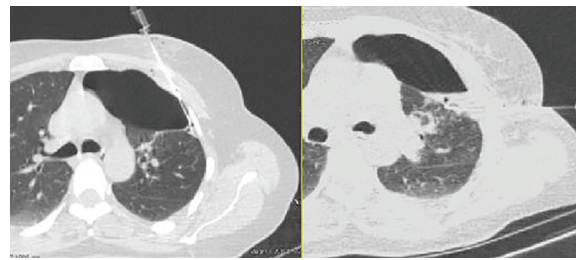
Under the guidance of a CT scan, a percutaneous injection of 1 cc pure cyanoacrylate glue into the BPF orifice was performed.
